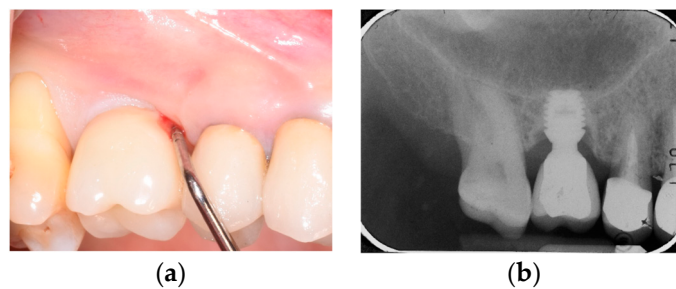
Clinical and radiographic signs of peri-implantitis after 5 years from loading. See bleeding on probing with increased PPD (a) and apical migration of the F-BIC greater than 1 mm (b).
